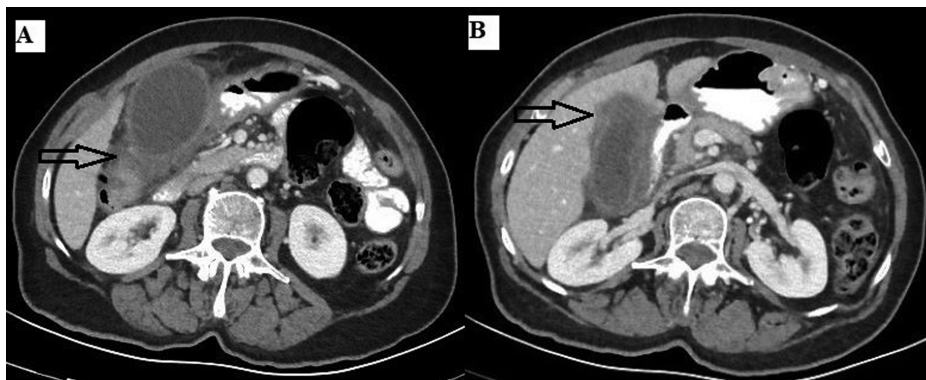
Abdominal CT images were taken at the first admission of a 61-year-old female patient diagnosed with gallbladder perforation intraoperatively. (A, B): Axial CT image, postcontrast venous phase. It shows significant contrast enhancement in the gallbladder wall, wall thickening, and pericholecystic diffuse edema and inflammation in the adipose tissue. CT, computed tomography.
